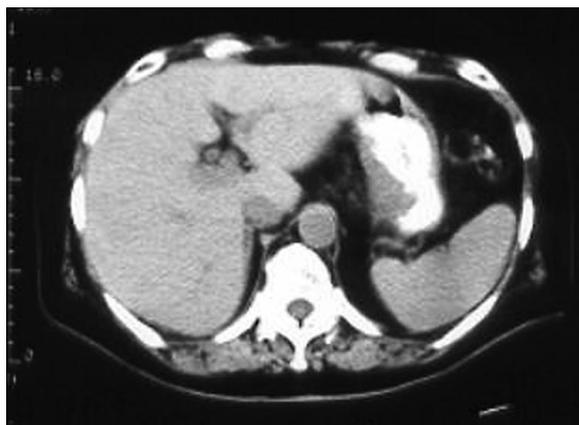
Initial precontrast CT scan. The spleen looks intact. Thickening of the stomach wall represents most likely neoplastic infiltration.
